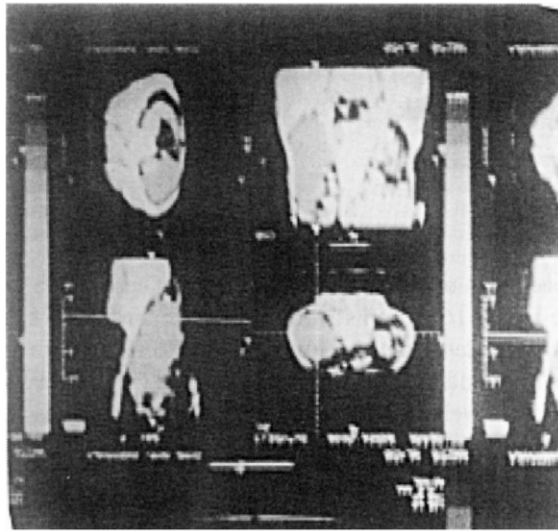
CT scan showing a large retroperitoneal cyst, displacing the left kidney medially
